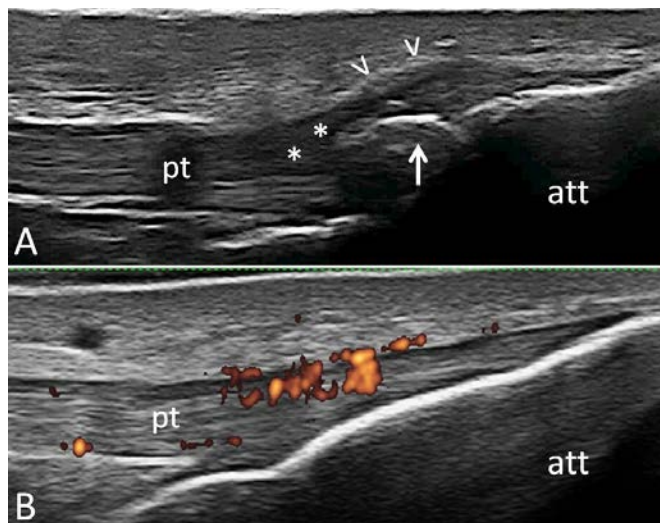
(A) Metabolic syndrome: longitudinal scan of patellar tendon at its distal insertion into the anterior tibial tuberosity. Note the presence of hypoechoic areas (asterisks), enthesal thickening (arrowheads) together with an enthesophyte (arrow). (B) Psoriatic arthritis: while no B-mode signs of enthesitis are detectable, the image shows evidence of intense power Doppler signal at the enthesal area. att, anterior tibial tuberosity; pt, patellar tendon.
